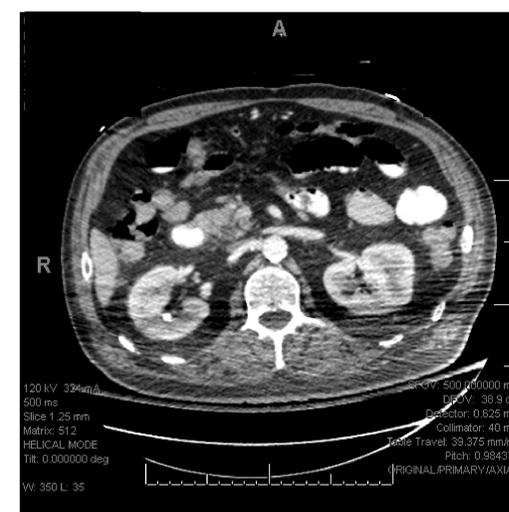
CT Scan: -Day 15
